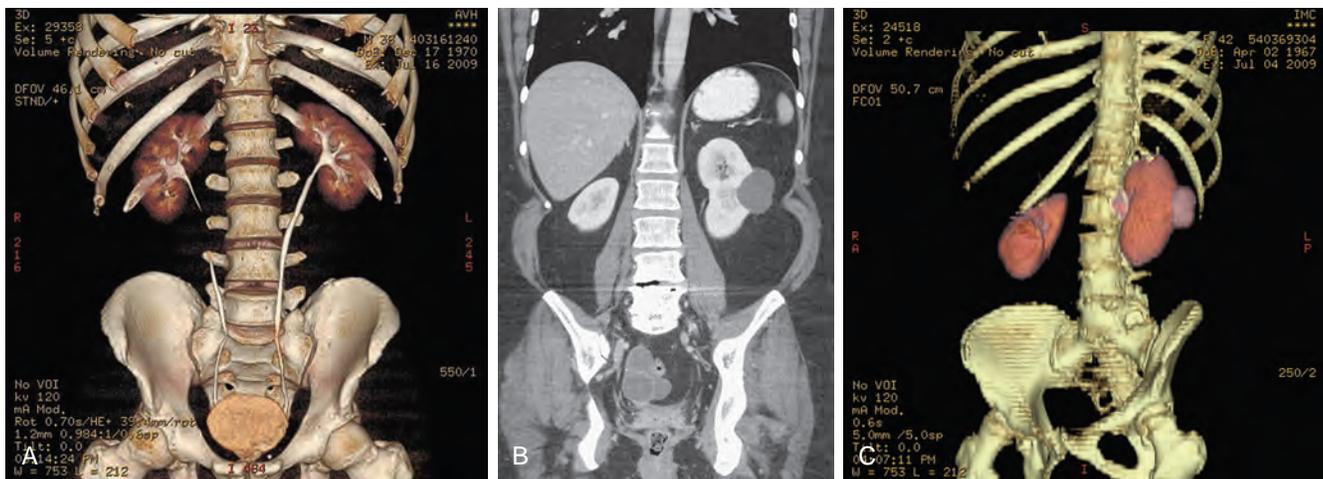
(A) 3D colored reconstruction of the kidneys ureter and bladder from CT urogram. (B) Coronal reconstruction in a patient with a clear cell renal cell carcinoma in a complex renal cystic mass and enhancing mural nodule. (C) 3D reconstruction of the same patient with slight posterior rotation.
